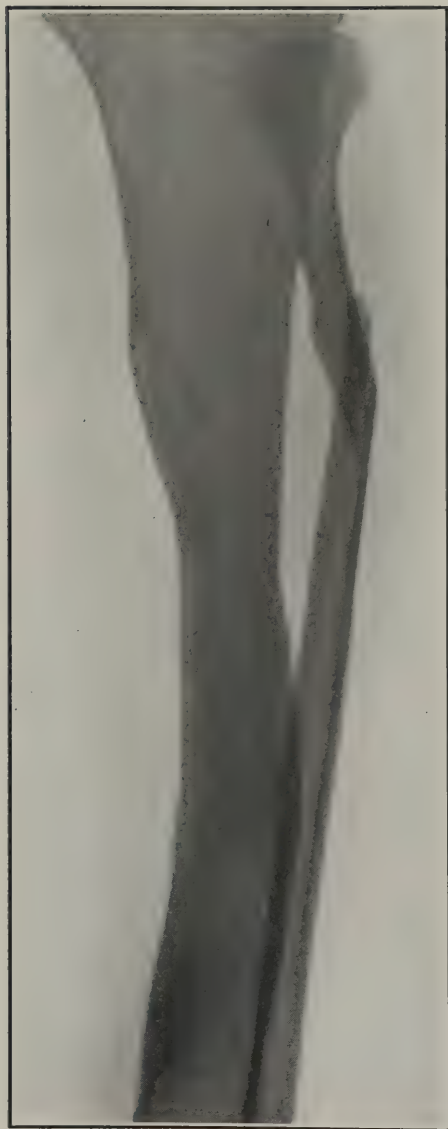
Case 1. Roentgenogram, May, 1924, showing hypertrophy of graft in tibia
